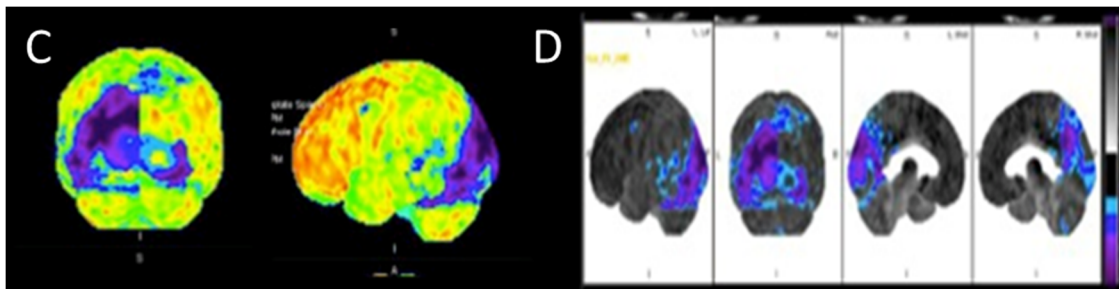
^{18}F -FDG PET for Epilepsy C) SSP (stereotactic surface projection) Inter-Ictal scan
